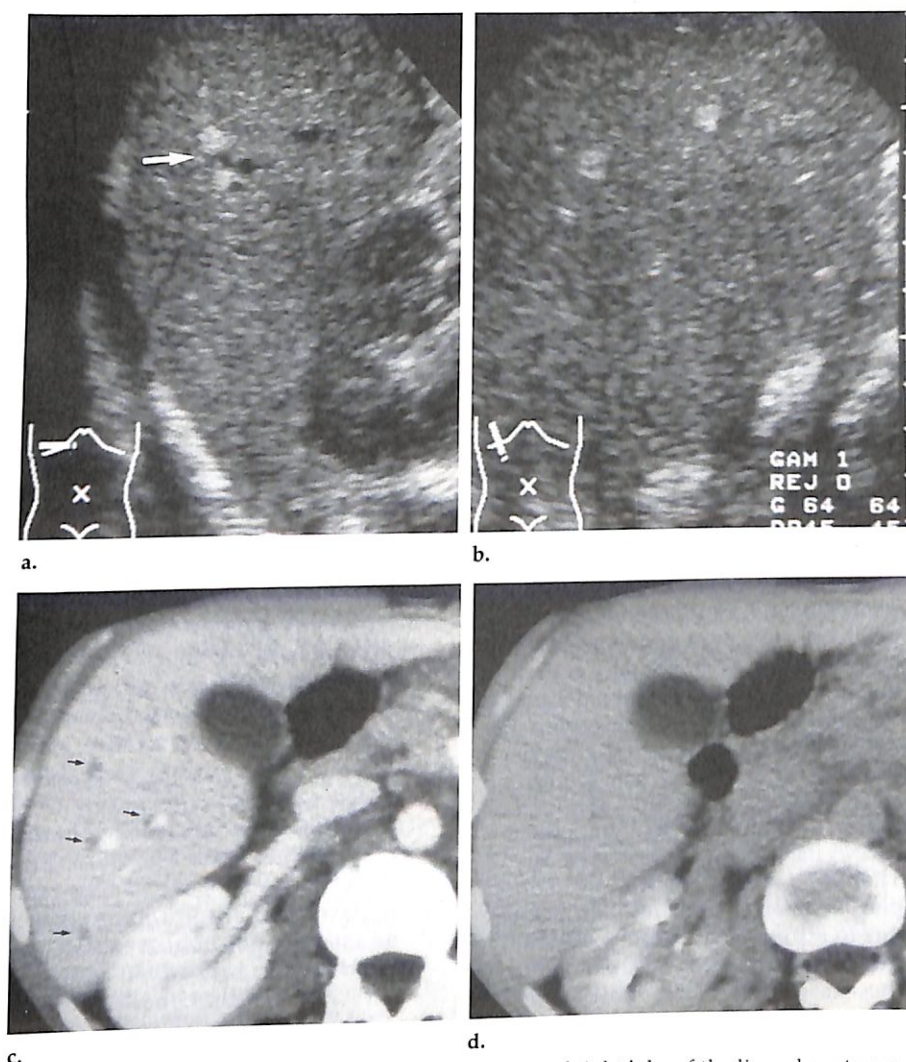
Case 2. Axial (a) and oblique (b) sonograms of right lobe of the liver show hyperechoic Kaposi sarcoma nodules, some clearly adjacent to portal veins (arrow). (c) Dynamic CT scan shows low-attenuation periportal lesions grossly mimicking dilated biliary ducts (arrows). (d) Delayed CT scan obtained at same level as that in b shows that the lesions have enhanced and are not visible.
